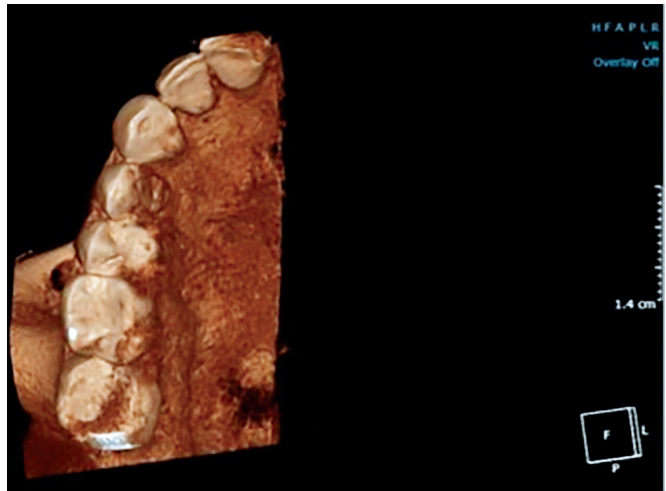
Cone Beam Computed Tomography for planning.
